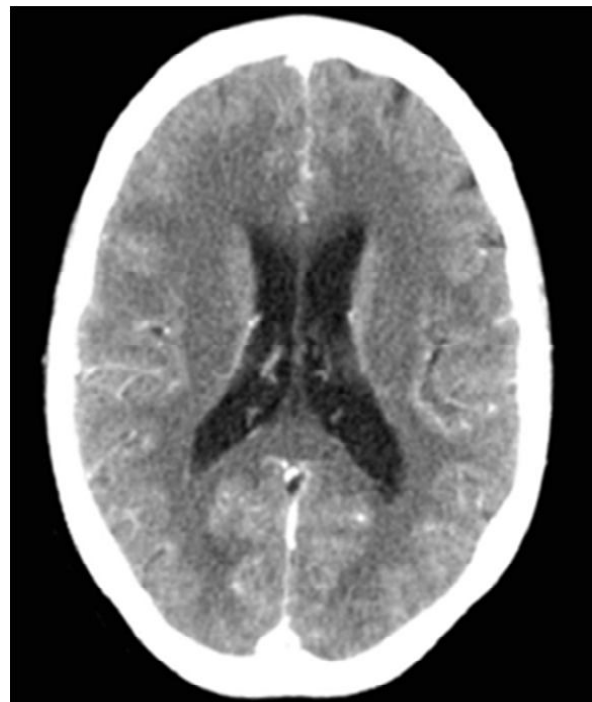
Contrast-enhanced computed tomography of the head showing diffuse meningeal enhancement in brain sulci and across sinuses
